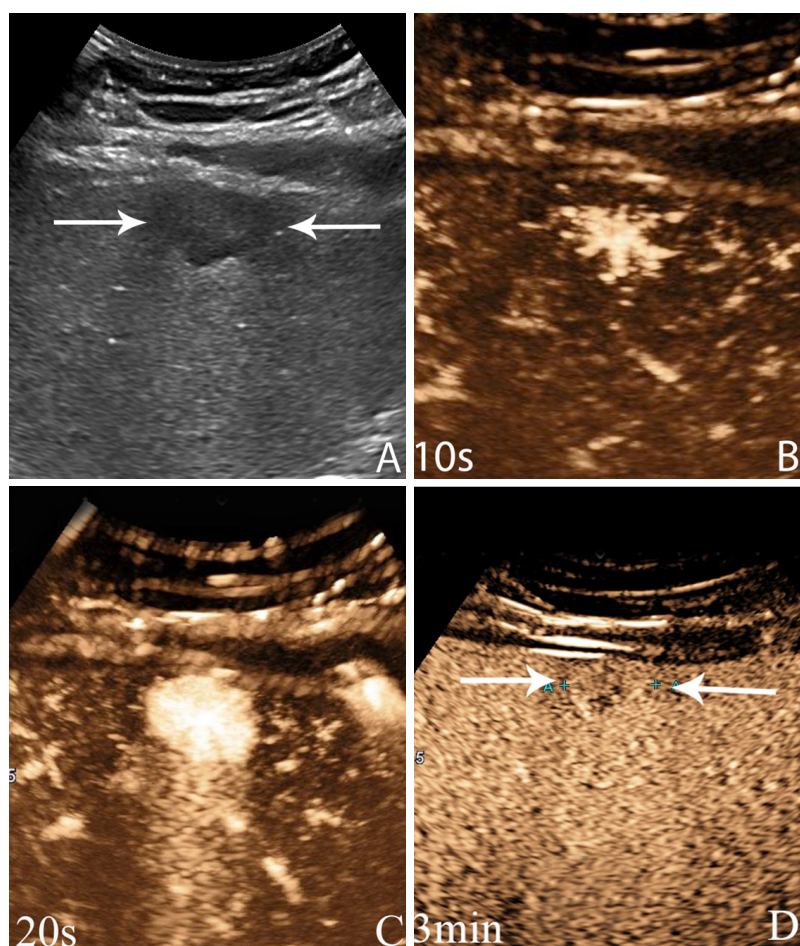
Focal nodular hyperplasia. 25-year-old woman with an incidentally discovered liver mass found during ultrasound performed for examination of her bowel. An incidentally discovered superficial focal hypoechoic liver mass (A); an early arterial phase (AP) image shows a stellate pattern of linear vessels in the center of the mass (B); at the peak of AP enhancement, the mass is brightly and uniformly enhanced (C); at 3 min, the mass continues to show sustained enhancement greater than the adjacent liver (D)
